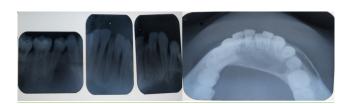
Intraoral radiographs shows unilocular radiolucency extending from 32 to distal root of 46 with well-defined periphery and widening of PDL space, root resorption was seen irt 44,45,46. Distal displacement irt 45. Diffuse radiolucency with loss of lamina dura irt apical region of fractured 41 suggestive of periapical abscess irt 41 and OKC of body of mandible.
